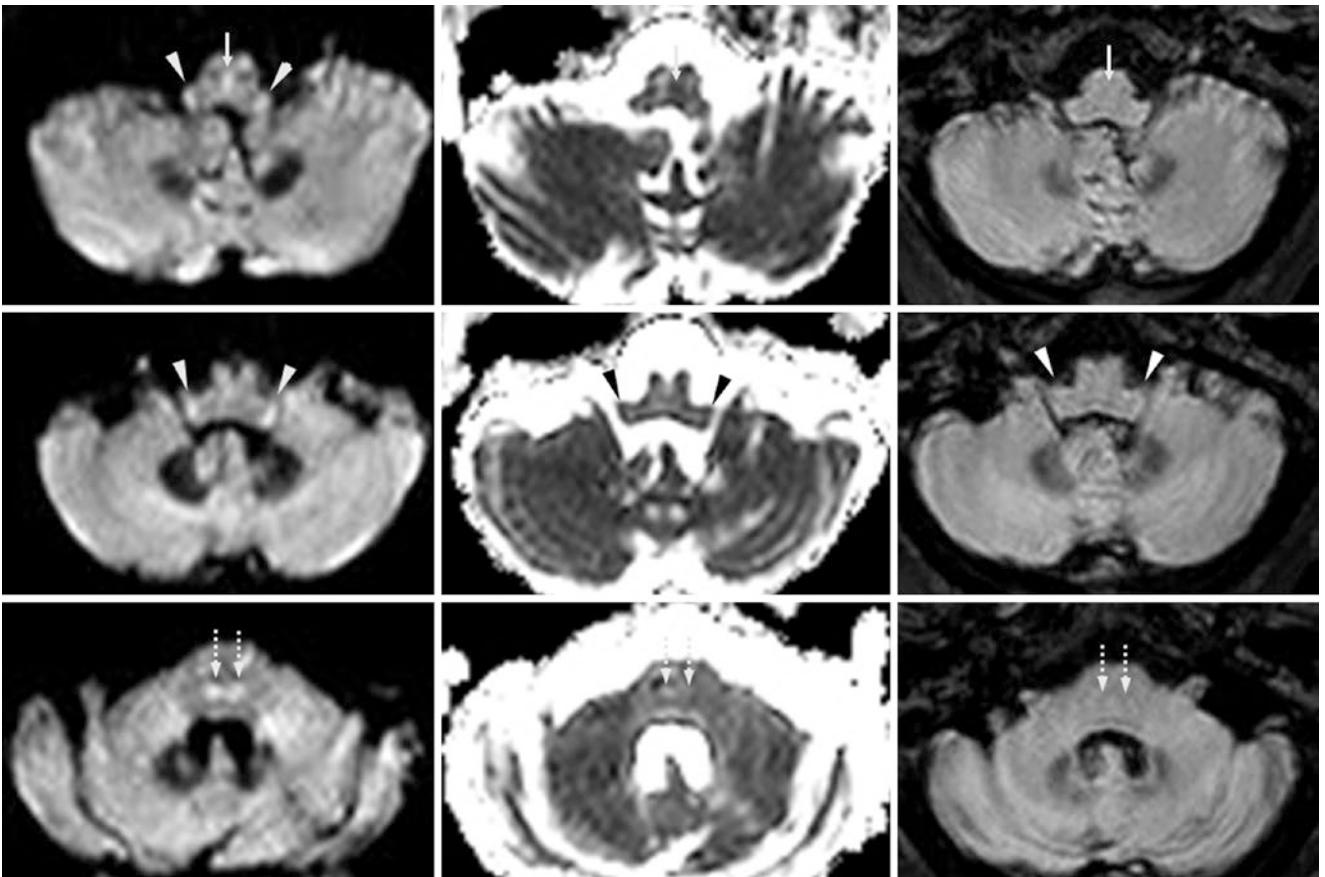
A 54-year-old with a normal 3 T MRI. *Top row:* There is hyperintensity within the pyramidal decussation (*thin arrows*) on DWI (*left*), without dark signal on the ADC map (*middle*) or on 3D-reformatted FLAIR (*right*). There is also bright signal on DWI within the inferior cerebellar peduncles (ICPs) bilaterally (*arrowheads*). *Middle row:*
